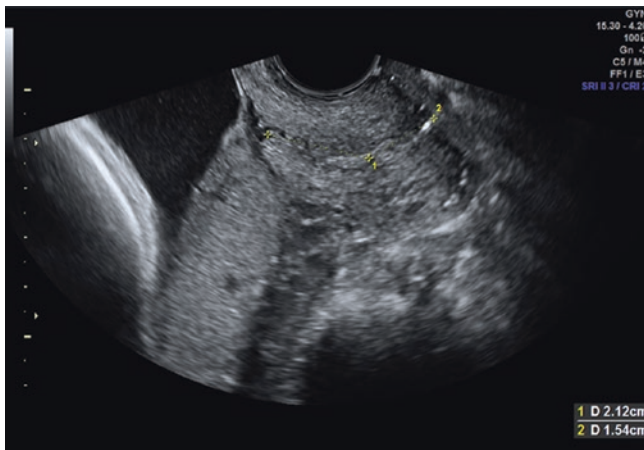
Placental edge shape at transvaginal ultrasound
